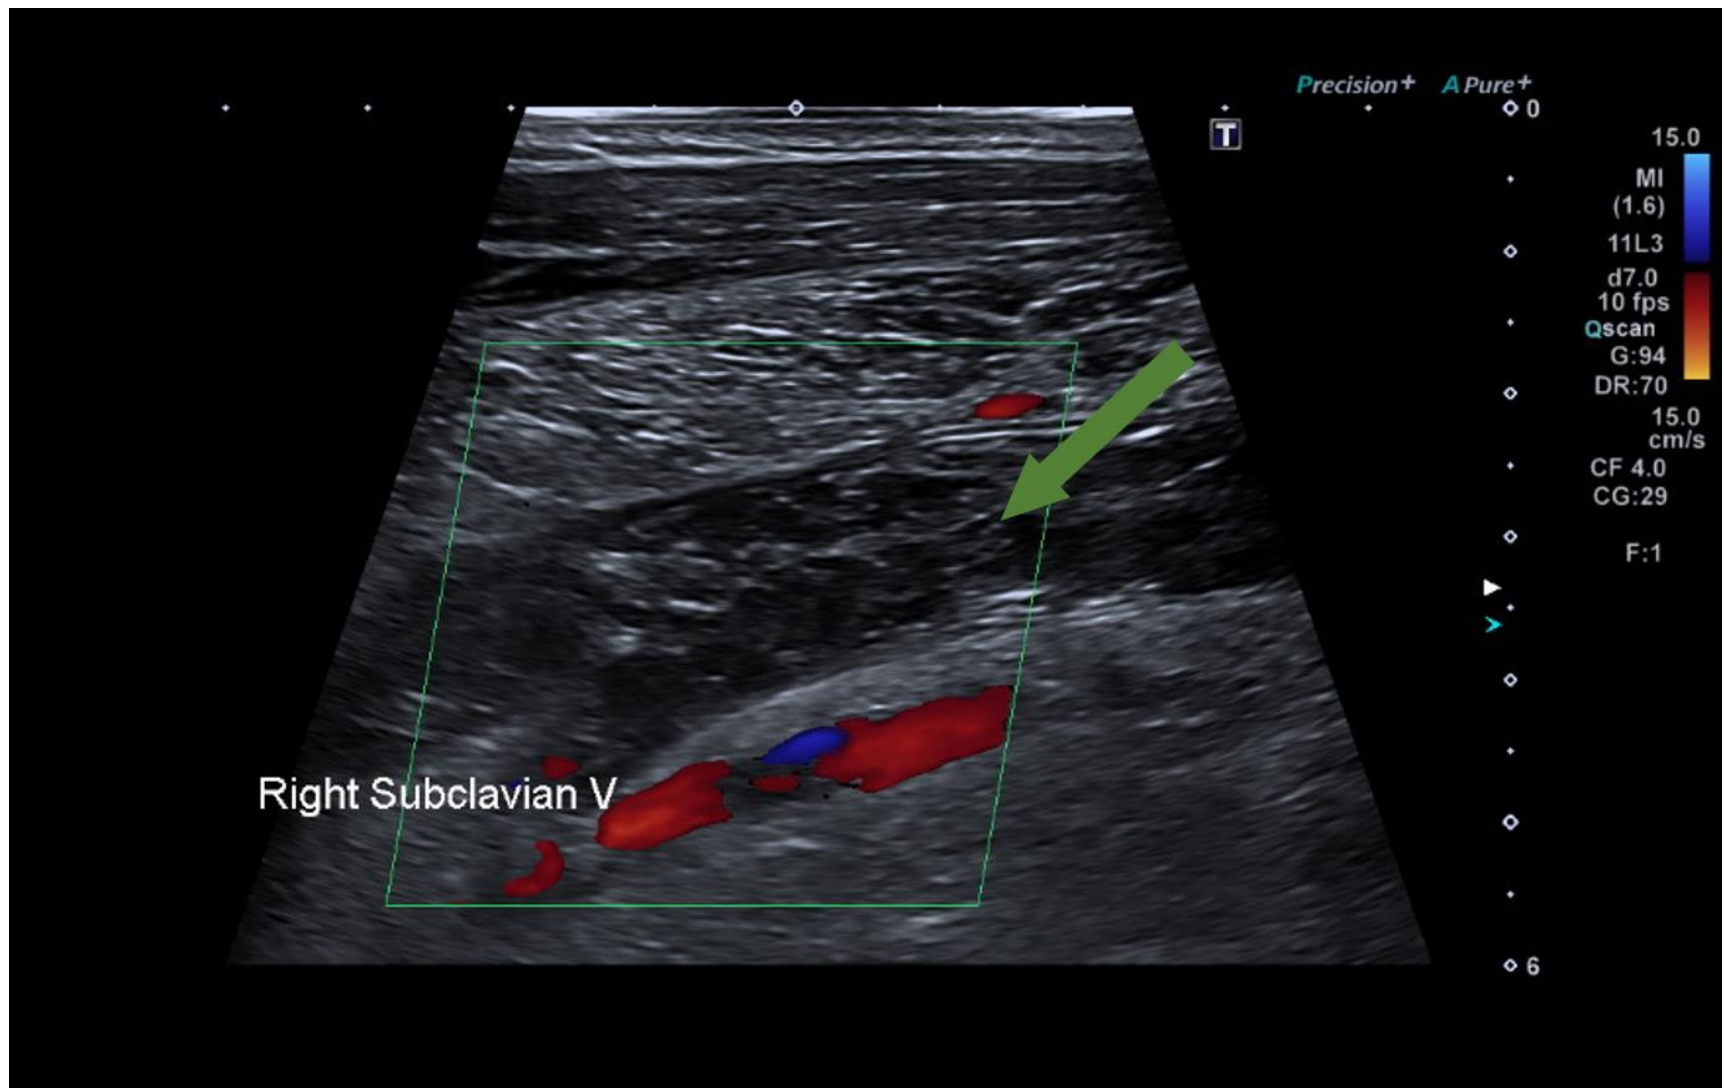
A Duplex (B-mode and colour Doppler) longitudinal image of the right subclavian vein (green arrow). There is mixed echogenicity thrombus within and a complete absence of blood flow to the vein. (Hospital "X", 2023).
